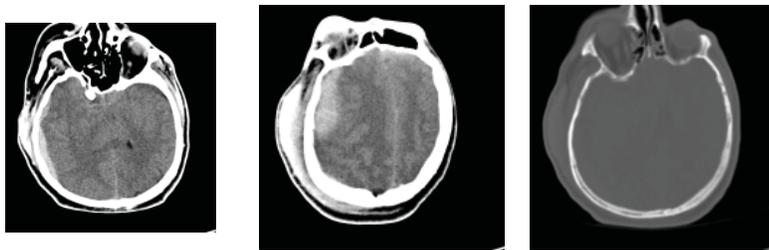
CT Brain done upon the patient arrival to RR. (a) 2 small right temporal and occipital small acute EDHs. (b) another right frontal small acute EDH. (c) temporal bone linear fracture that caused the hematoma
